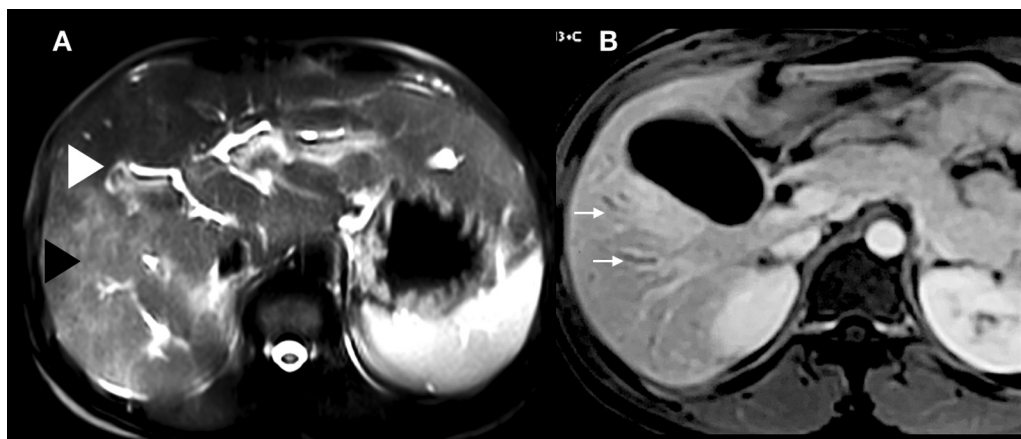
A 55-year-old male with case of primary sclerosing cholangitis (PSC) on follow-up. Axial T2-weighted (T2W) images (A) showing increased signal (black arrowhead) in the hepatic parenchyma with a prominent caudate lobe. Note dilated biliary radicles (white arrowhead). Postcontrast images (B) in a different patient who presented with altered liver function tests (LFTs) reveal increased periductal enhancement (arrows) around the dilated biliary radicles.
